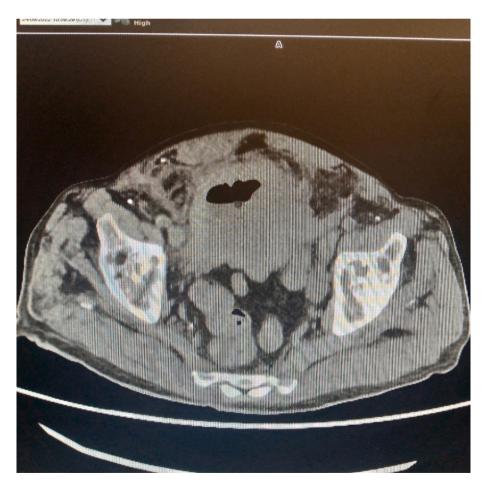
The CT scan revealing a bladder perforation and the presence of gas within the anterior bladder wall and retropubic space.
